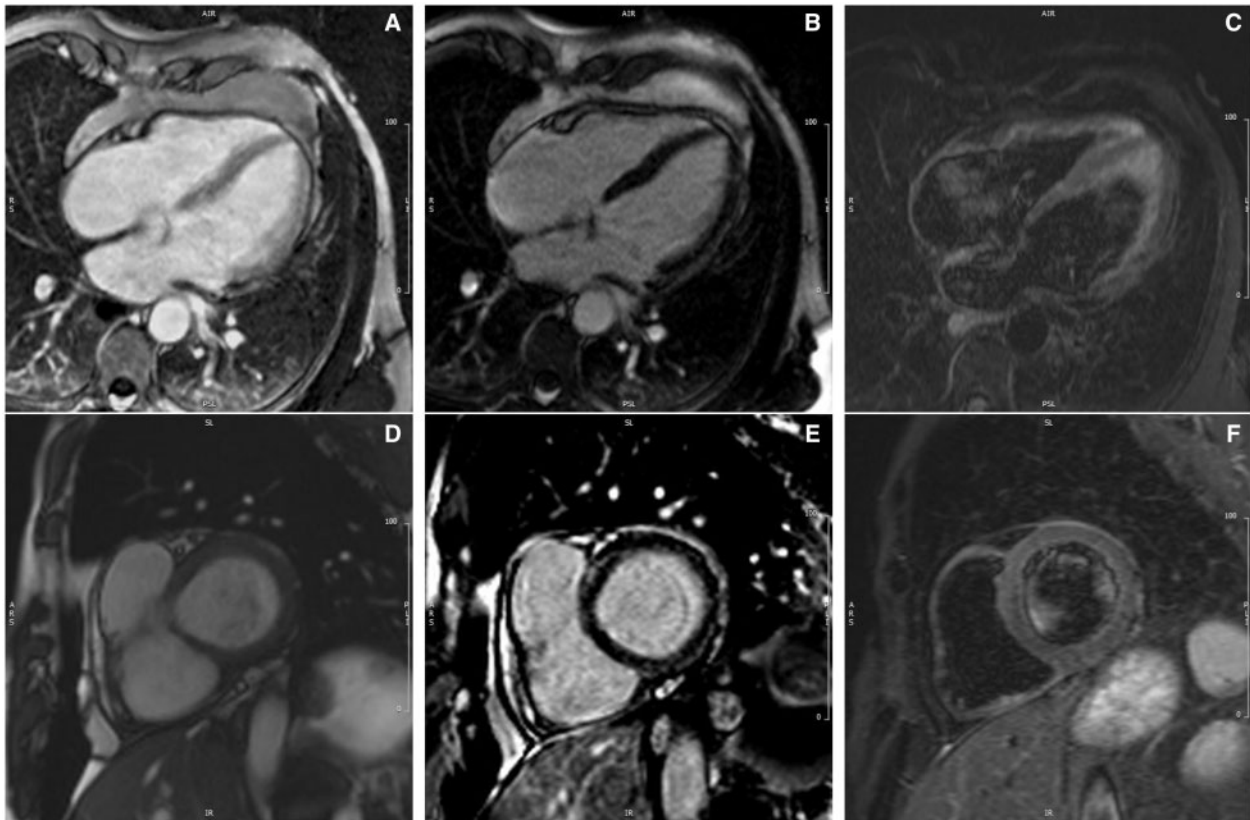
Third cardiac magnetic resonance imaging scan showing resolution of abnormalities seen in [Figure 2](#). (A) Four-chamber EGE, (B) four-chamber late gadolinium enhancement, (C) four-chamber STIR, (D) SAX CINE, (E) SAX post-contrast late gadolinium enhancement, and (F) SAX STIR imaging.
